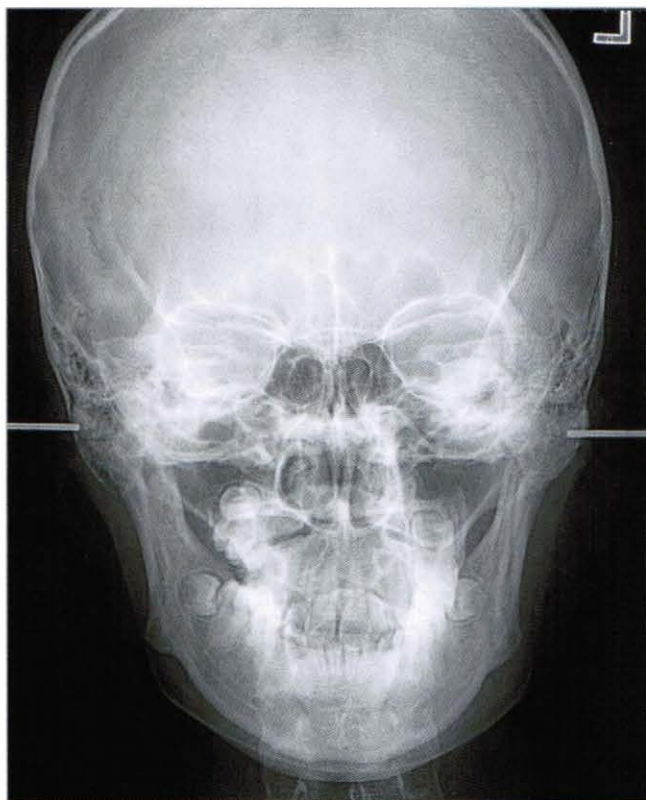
Pre-treatment postero-anterior radiograph
